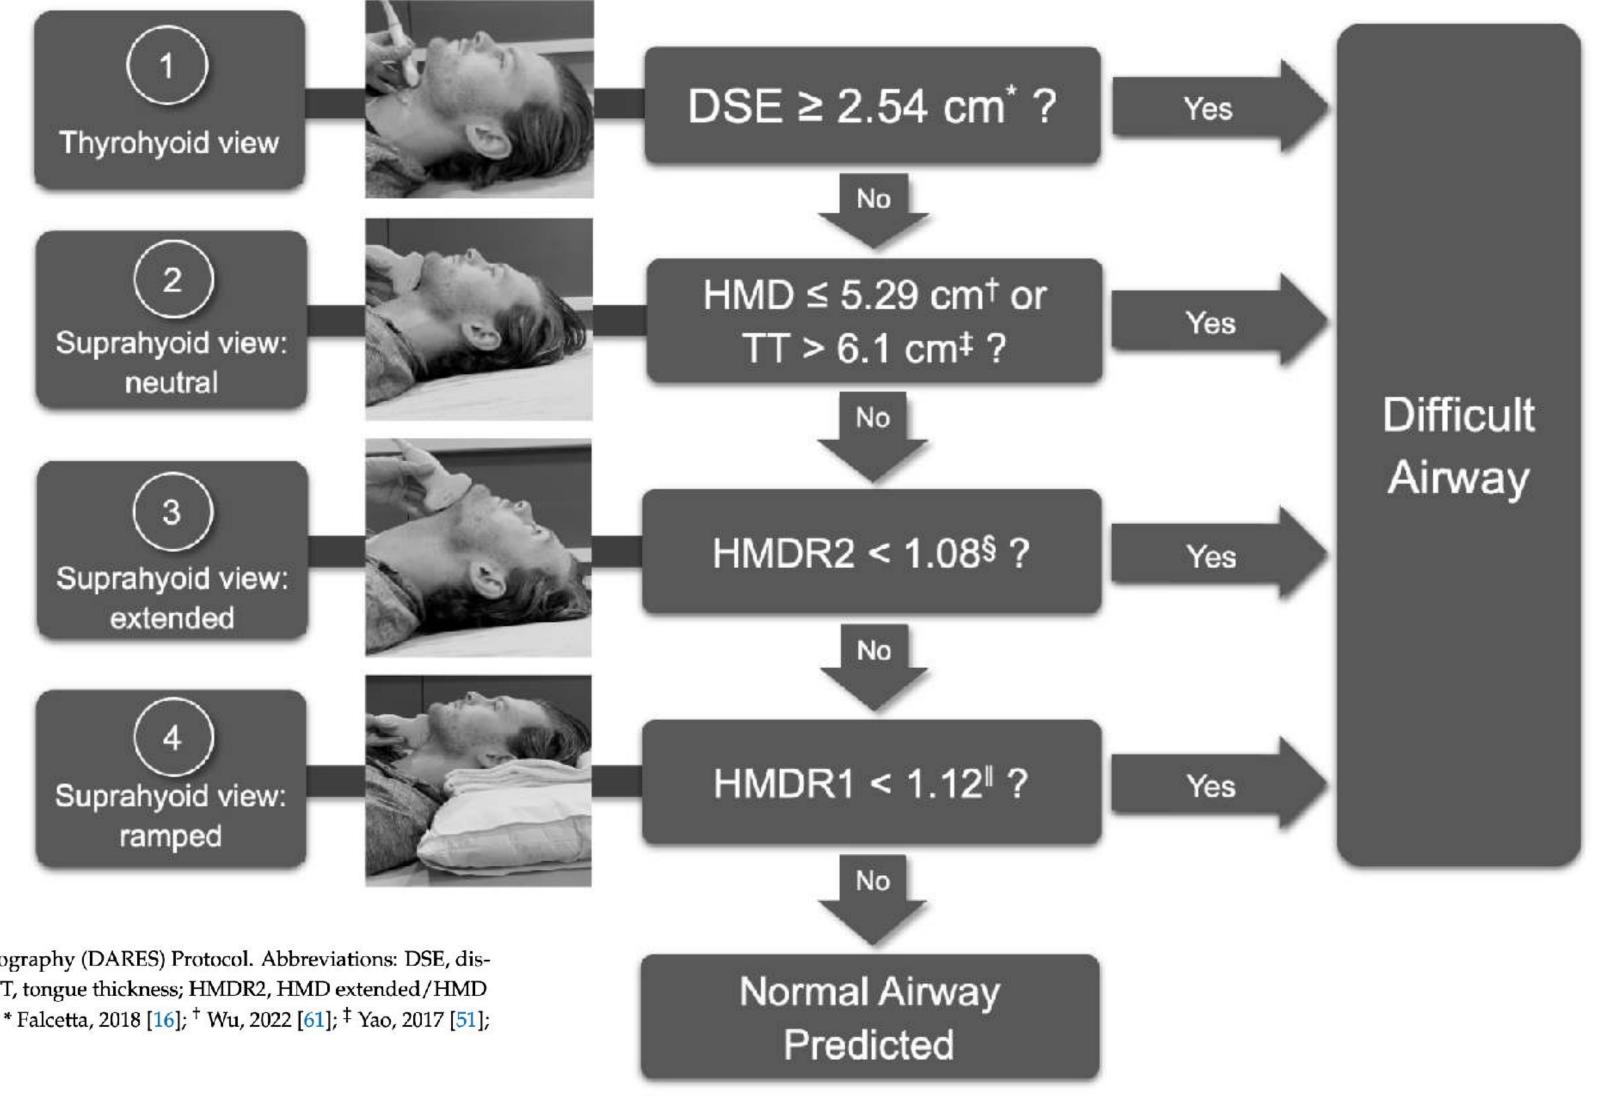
Difficult Airway Evaluation with Sonography (DARES) Protocol. Abbreviations: DSE, distance to epiglottis; HMD, hyomental distance; TT, tongue thickness; HMDR2, HMD extended/HMD neutral; HMDR1, HMD ramped/HMD neutral. * Falcetta, 2018 [16]; ⁺ Wu, 2022 [61]; [‡] Yao, 2017 [51]; [§] Rana, 2018 [44]; ^{||} Petrisor, 2018 [60].
